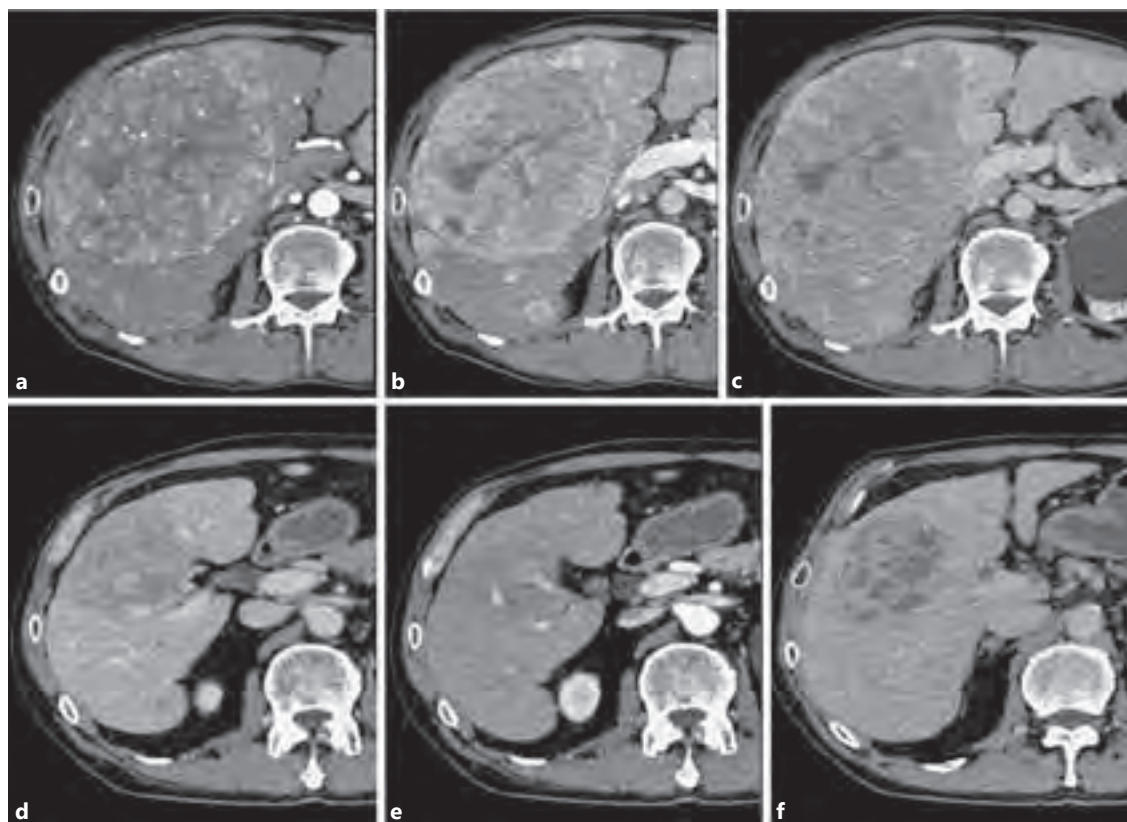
A 50-year-old man with a very large HCC achieved a PR following sorafenib administration. a–c Computed tomography scan performed before sorafenib treatment showing a huge HCC with intrahepatic metastases in the right lobe. a Arterial phase.
